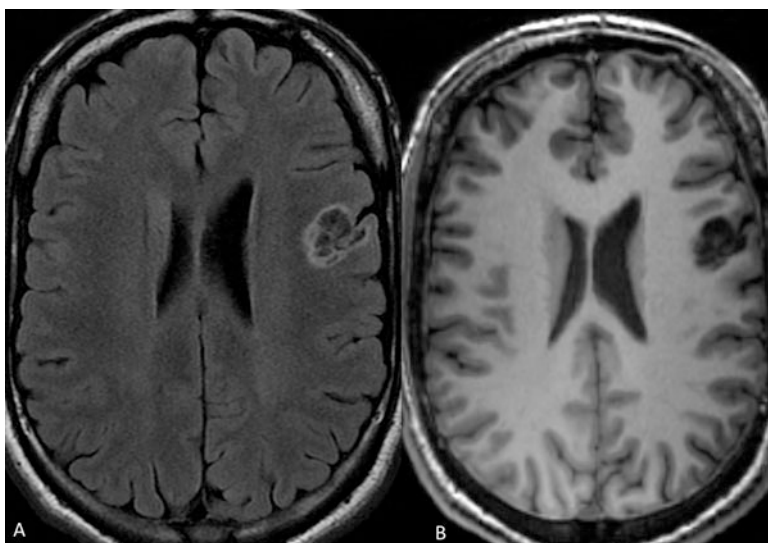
Pseudo-polycystic “bubbly” appearance of a left frontal type 1 DNET in axial FLAIR (a) and T1 (b)
